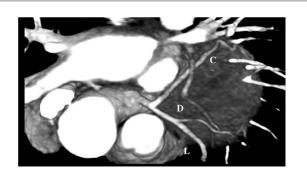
Volume-Rendered CTA Image
